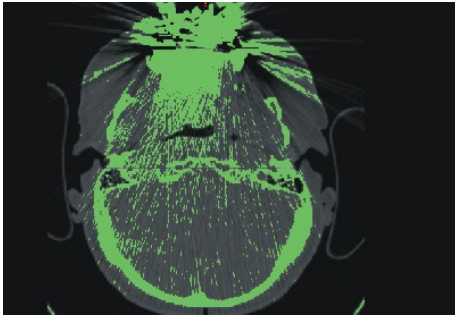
Patient with significant CT artifacts caused from prior dental bridgework.
